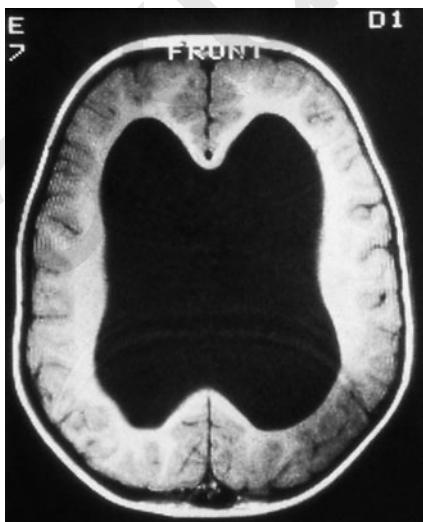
Computed tomographic scan of head showing dilated lateral ventricles.
